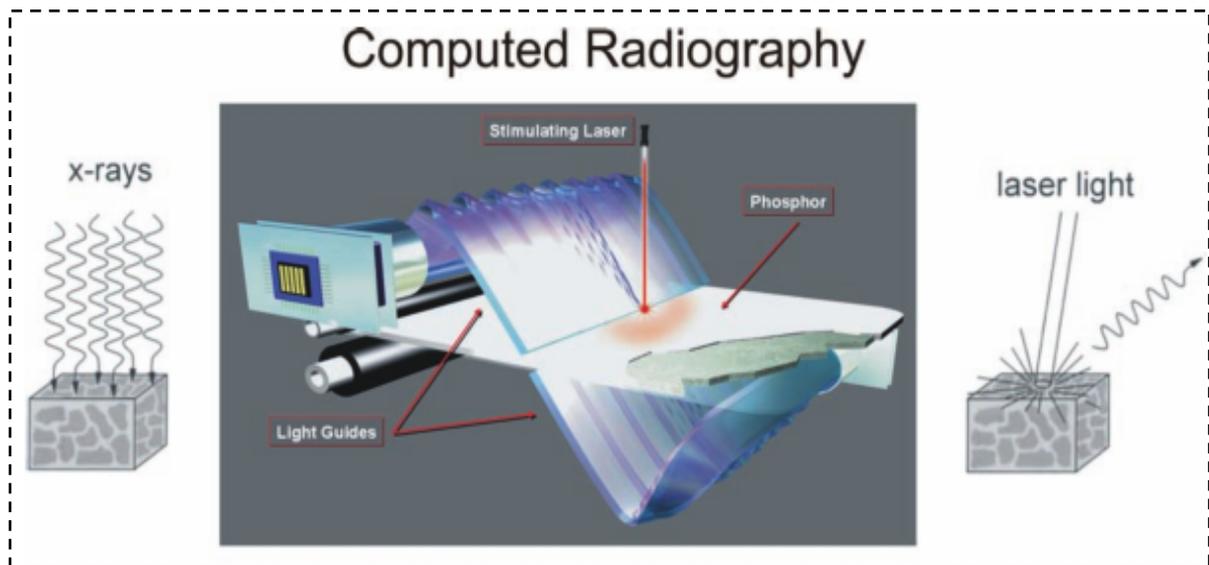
Computed radiography detectors. In (CR), x-rays excite a phosphor which traps the liberated charge (left). The phosphor plate is then raster-scanned by translating a plate past a scanning laser. The laser stimulates the emission of light (right). The stimulated light is collected by light guides and recorded to produce the radiograph. [15]
